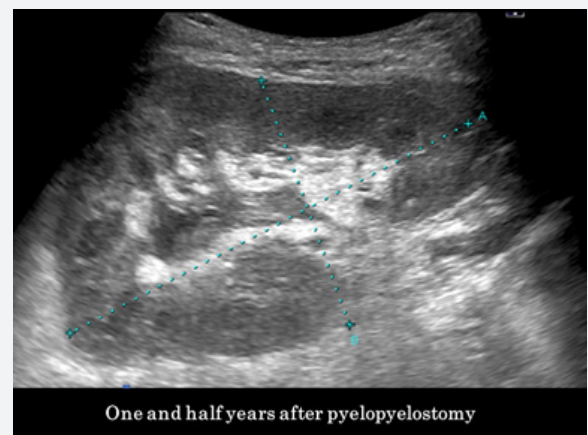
A recent ultrasound shows negligibly mild hydronephrosis without hydroureter or parenchymal atrophy.
